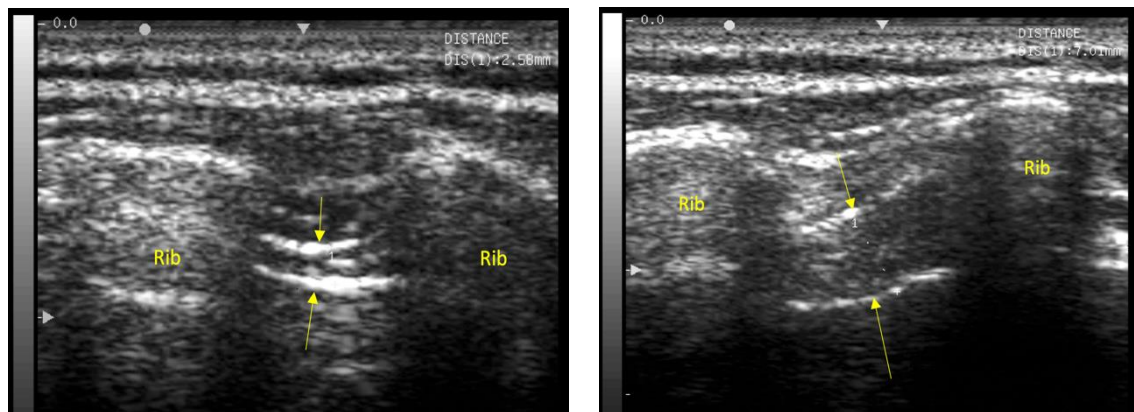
Ultrasound of the diaphragm thickness measurement at Tvex or tidal exhale (left image) and at Tmax or maximum inhale (right image). Key: Yellow arrows depict the top and bottom boundaries of the diaphragm muscle. Source: authors own images.
